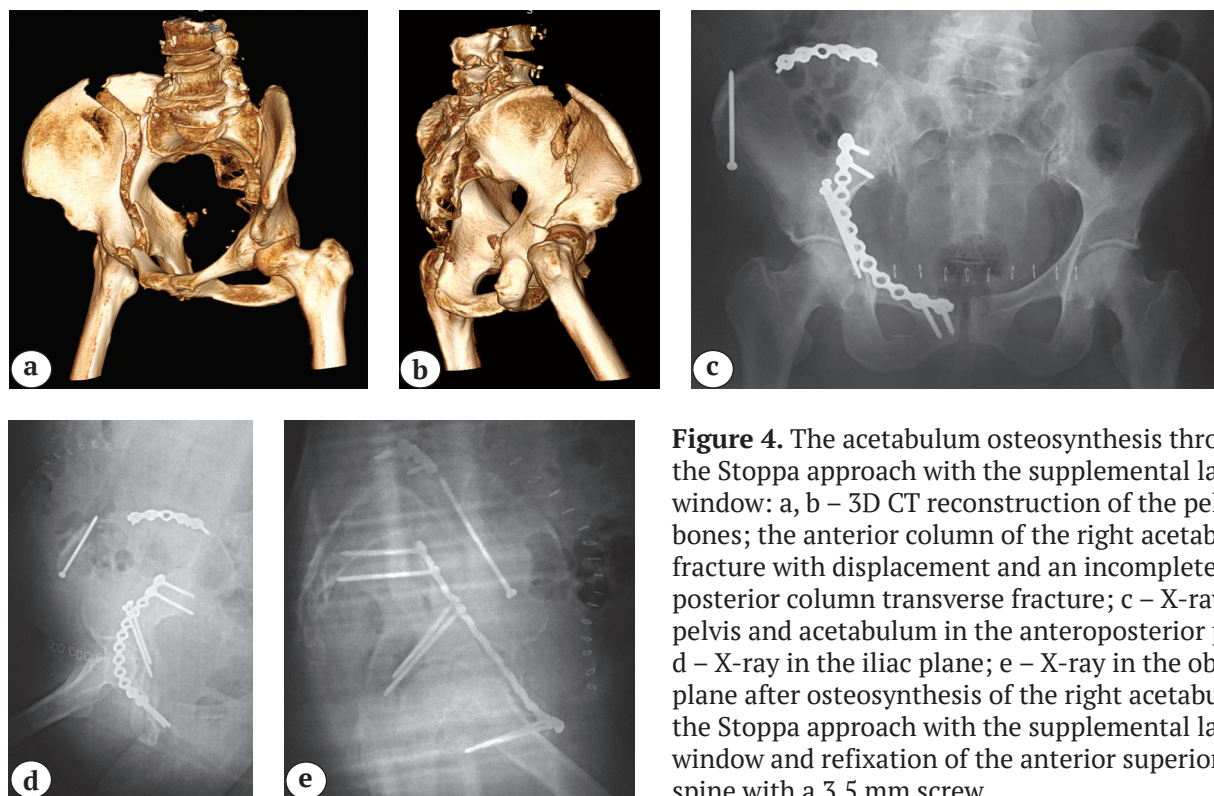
The acetabulum osteosynthesis through the Stoppa approach with the supplemental lateral window: a, b – 3D CT reconstruction of the pelvic bones; the anterior column of the right acetabulum fracture with displacement and an incomplete posterior column transverse fracture; c – X-ray of the pelvis and acetabulum in the anteroposterior plane; d – X-ray in the iliac plane; e – X-ray in the obturator plane after osteosynthesis of the right acetabulum by the Stoppa approach with the supplemental lateral window and refixation of the anterior superior iliac spine with a 3.5 mm screw
